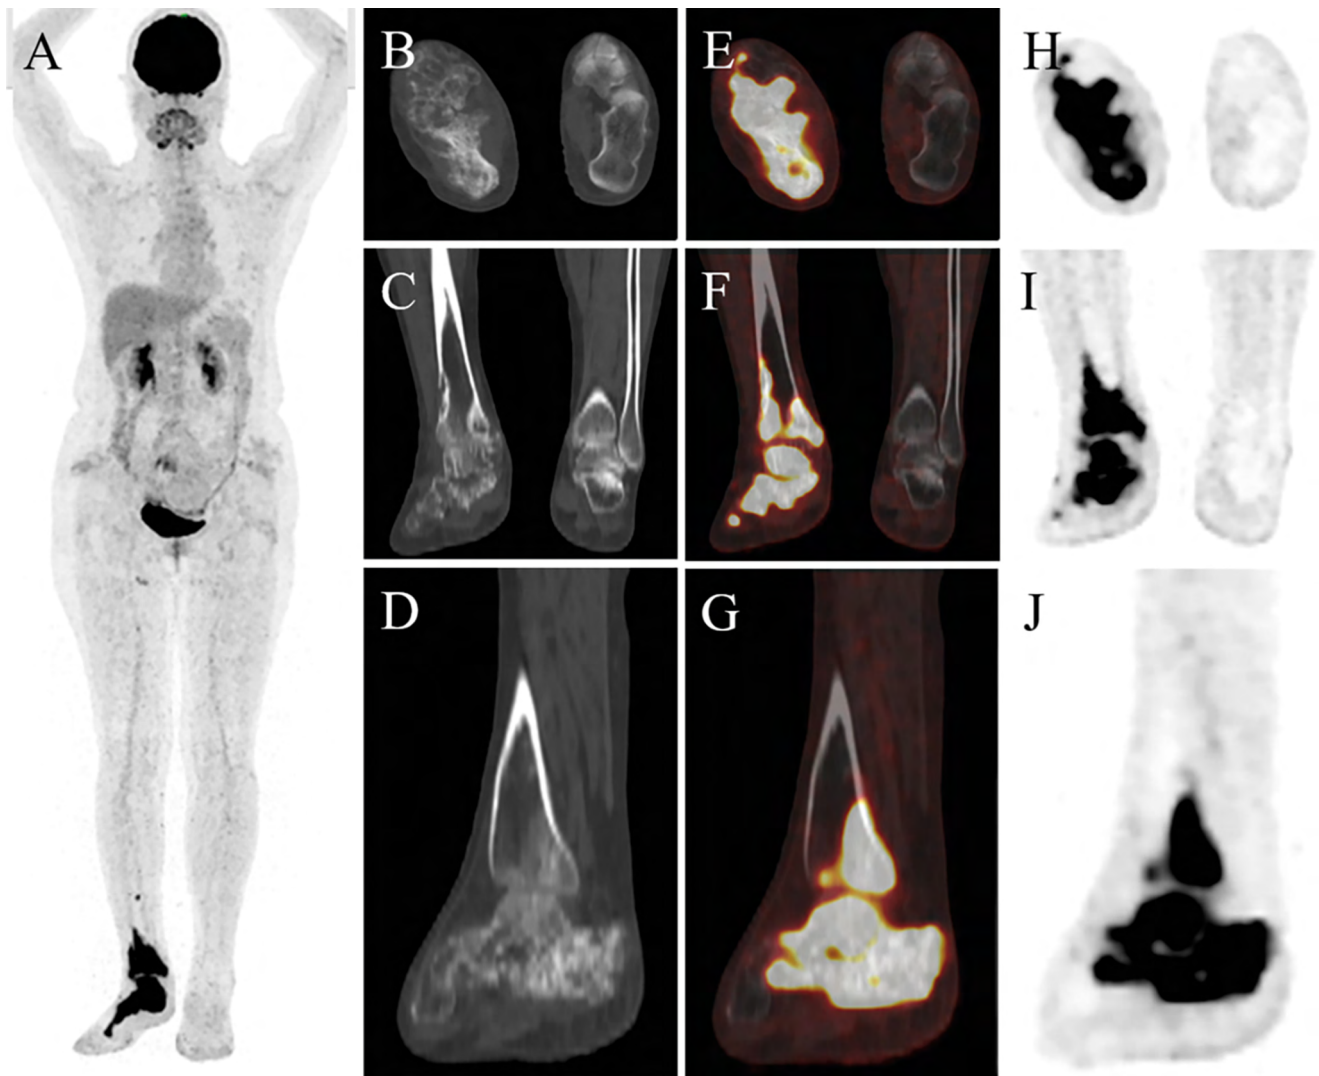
Maximum intensity projection (A), axial, sagittal, coronal CT bone windows (B–D), PET/CT fusion imaging (E–G), and PET (H–J) imaging demonstrated multiple mixed bone destruction in the right distal tibia and fibula, calcaneus, talus, navicular, cuboid, lateral cuneiform bone and the second, third and fifth metatarsal bone with increased [^{18}F]FDG uptake
